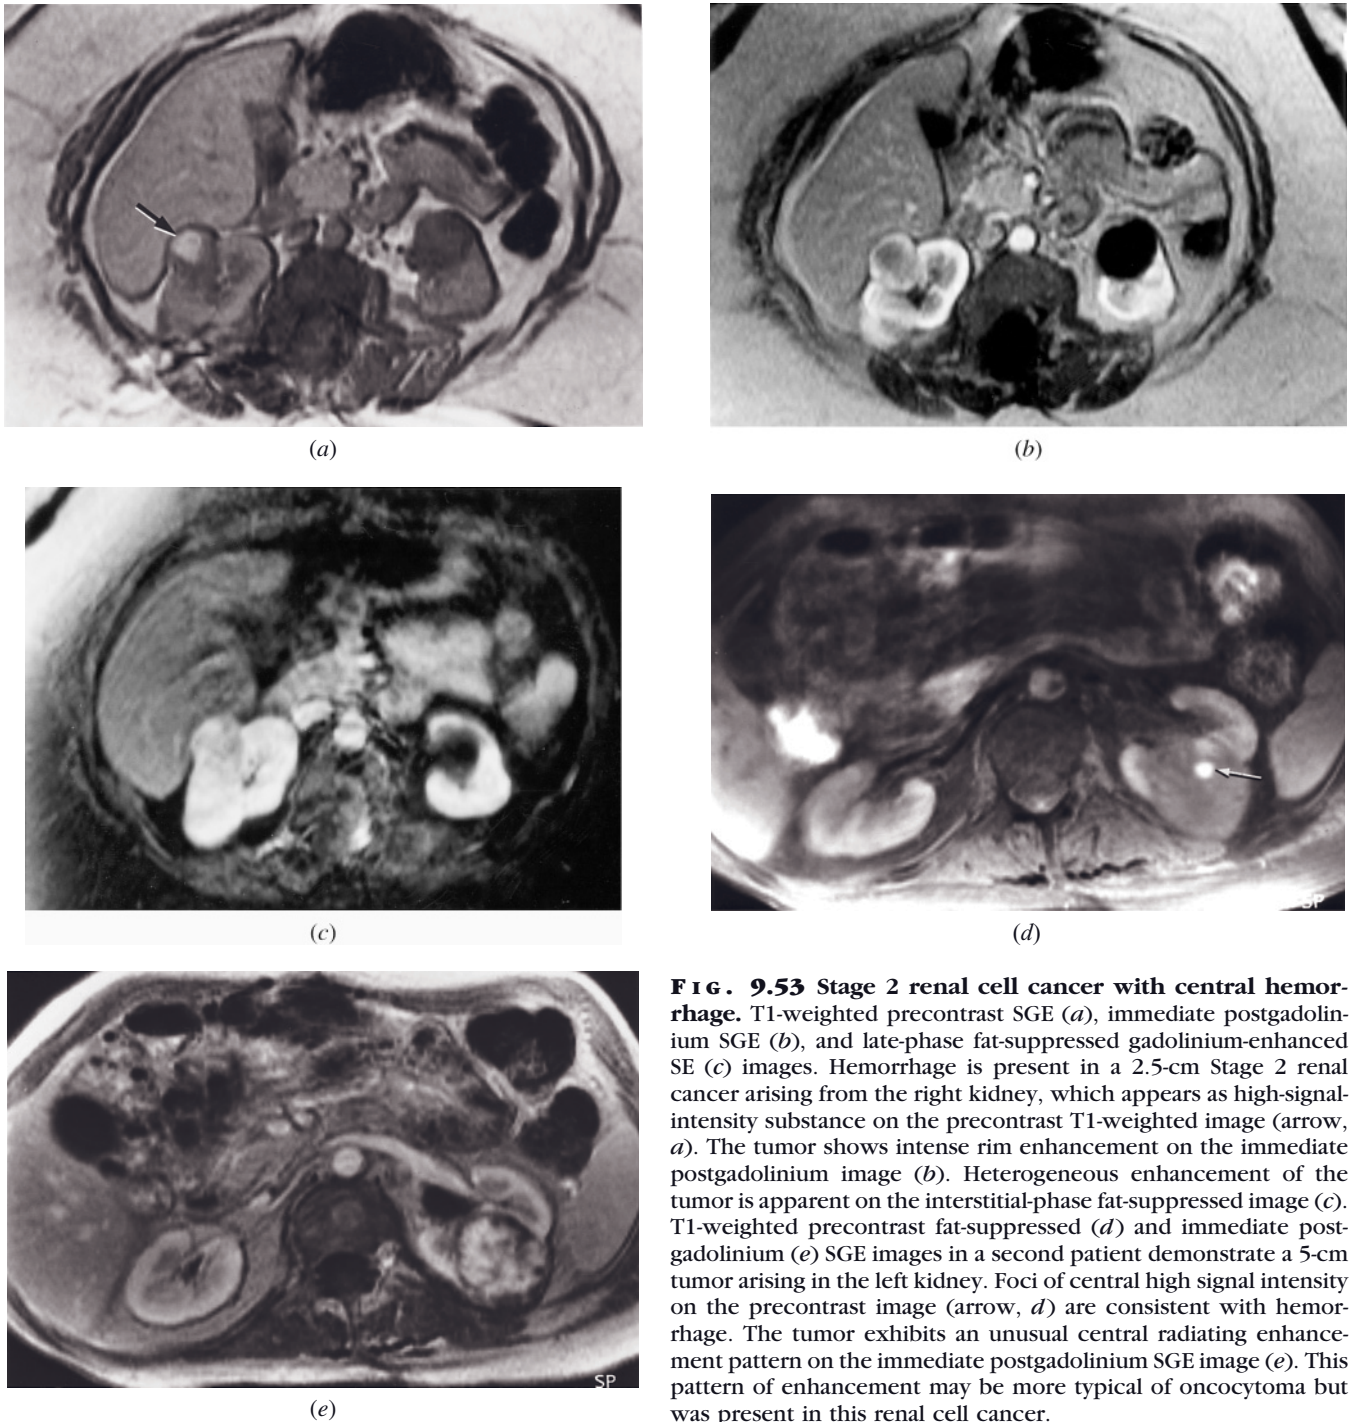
Stage 2 renal cell cancer with central hemorrhage. T1-weighted precontrast SGE (a), immediate postgadolinium SGE (b), and late-phase fat-suppressed gadolinium-enhanced SE (c) images. Hemorrhage is present in a 2.5-cm Stage 2 renal cancer arising from the right kidney, which appears as high-signal-intensity substance on the precontrast T1-weighted image (arrow, a). The tumor shows intense rim enhancement on the immediate postgadolinium image (b). Heterogeneous enhancement of the tumor is apparent on the interstitial-phase fat-suppressed image (c). T1-weighted precontrast fat-suppressed (d) and immediate postgadolinium (e) SGE images in a second patient demonstrate a 5-cm tumor arising in the left kidney. Foci of central high signal intensity on the precontrast image (arrow, d) are consistent with hemorrhage. The tumor exhibits an unusual central radiating enhancement pattern on the immediate postgadolinium SGE image (e). This pattern of enhancement may be more typical of oncocytoma but was present in this renal cell cancer.
